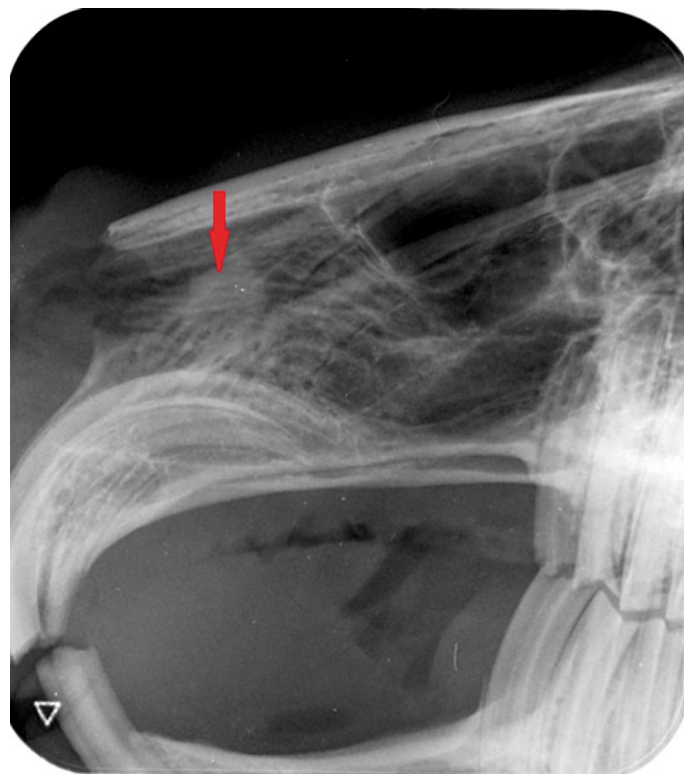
Radiograph taken on dental film. The right nasal concha lesion is marked with an arrow
